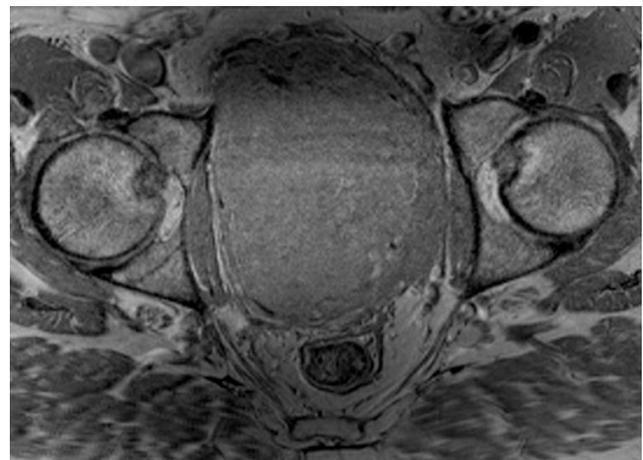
37-year-old male with solitary fibrous tumor of the prostate. Axial T1-weighted image demonstrates large, isointense mass replacing entire prostate.
